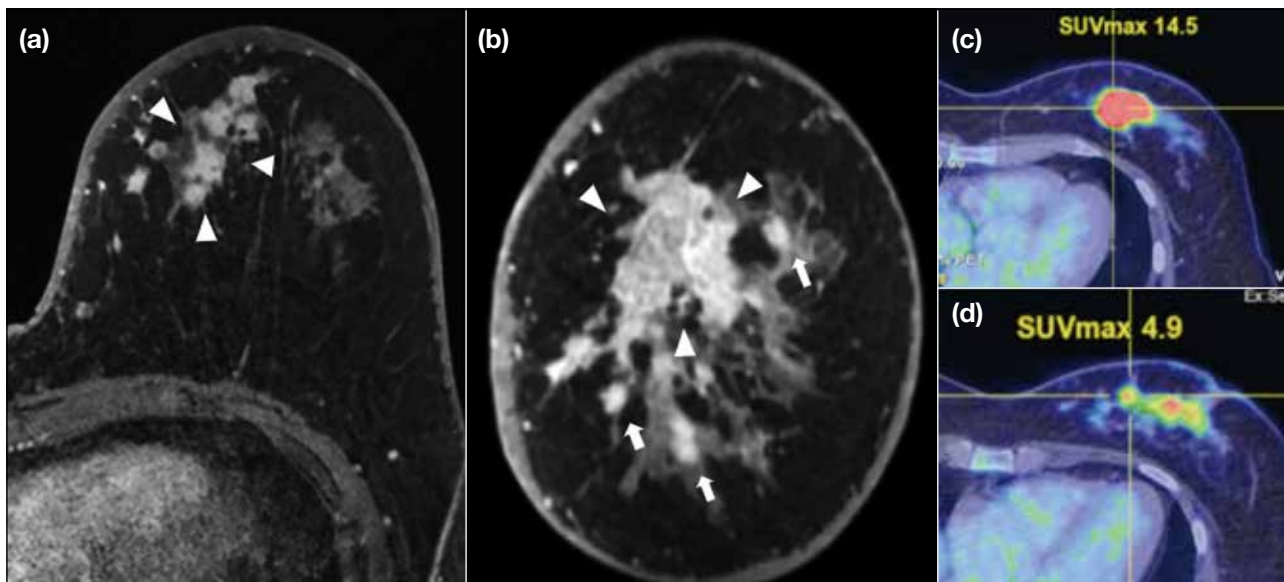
A 55-year-old woman with multicentric luminal B human epidermal growth factor receptor 2 + breast cancer (oestrogen receptor 90%, progesterone receptor 60%, *c-erbB2* 2+, and Ki-67 ~30%). (a) Axial and (b) coronal contrast-enhanced T1-weighted magnetic resonance images showing an irregular enhancing mass with spiculated margins in the upper inner quadrant of the left breast (arrowheads) with multiple smaller enhancing foci (arrows in [b]) in the lower inner and upper outer quadrants of the left breast, consistent with multicentric disease. (c and d) Corresponding fusion images of positron emission tomography/computed tomography depict a lobulated hypermetabolic mass in the upper inner quadrant (maximum standardised uptake value [SUV_{max}] = 14.5) and multiple small hypermetabolic foci in the lower inner quadrant (SUV_{max} = 4.9), again consistent with multicentric disease.
